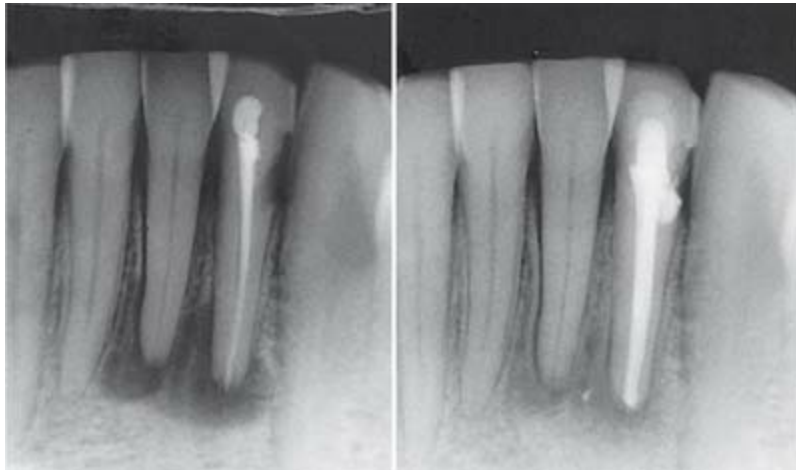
Initial radiograph was misleading and implicated tooth #23 and tooth #24. Pulp testing indicated a vital pulp in tooth #24, and it was not treated. Retreatment of #23 resulted in healing of the periradicular lesion.
